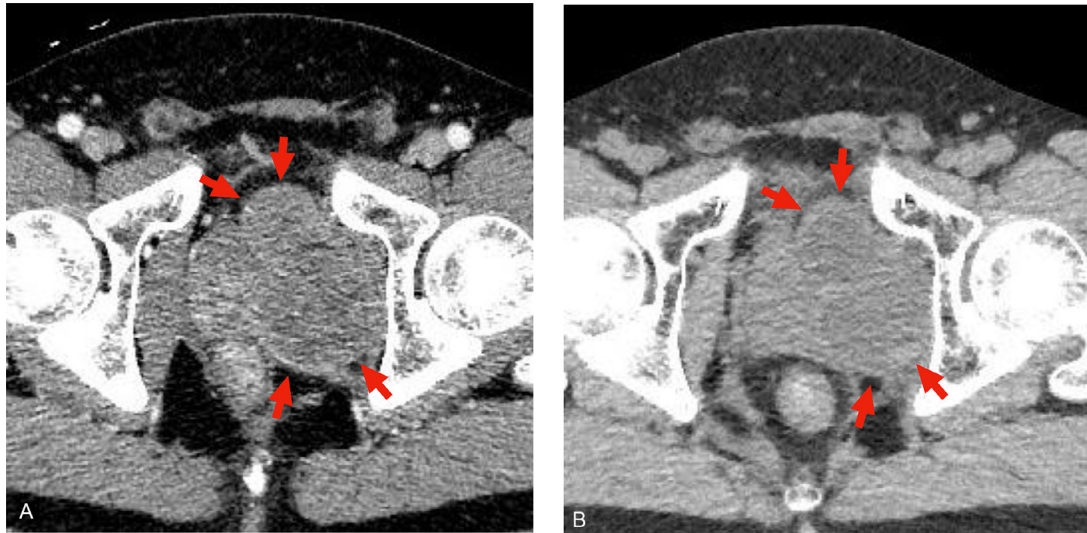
Computed tomography images (A) before the carbon ion radiotherapy and (B) 13 months after completion of the treatment show no remarkable change in the tumor size (red arrows).
